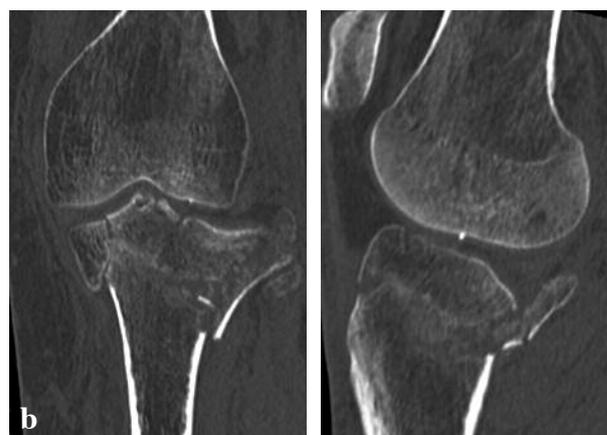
Pre-operative radiographs (a) and computer tomography scan (b) of a 58-year-old patient with a severe comminuted lateral tibial plateau fracture type B3. Postoperative radiographs (c) after TKA through a lateral approach with a tuberosity osteotomy.
